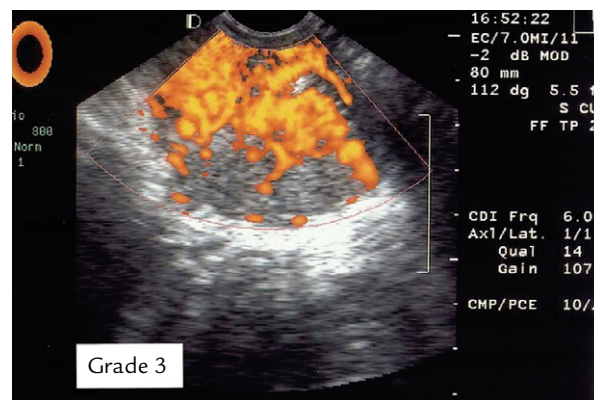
Power Doppler ultrasound shows grade 3 vascularity ($50\% < \text{vascular ratio} < 100\%$) within the tumor.
